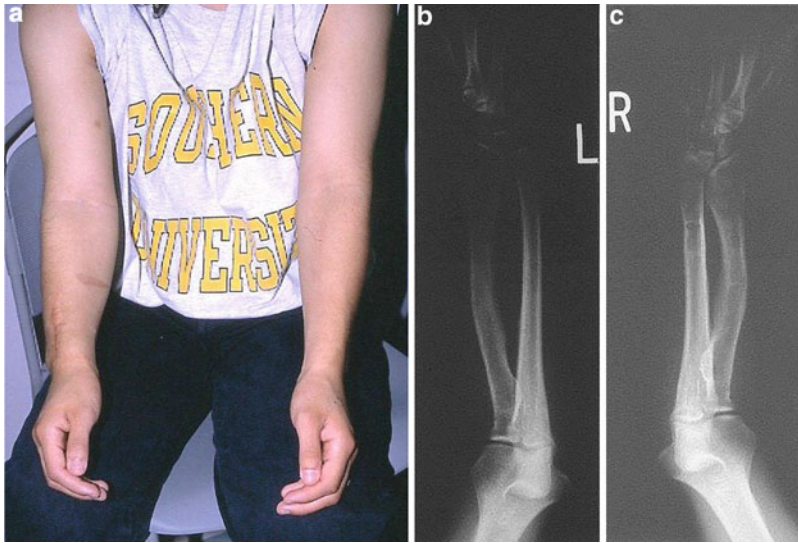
A young lady with Leri-Weill syndrome with short forearms and Madelung deformity (a) demonstrated by radiographs (b, c)
